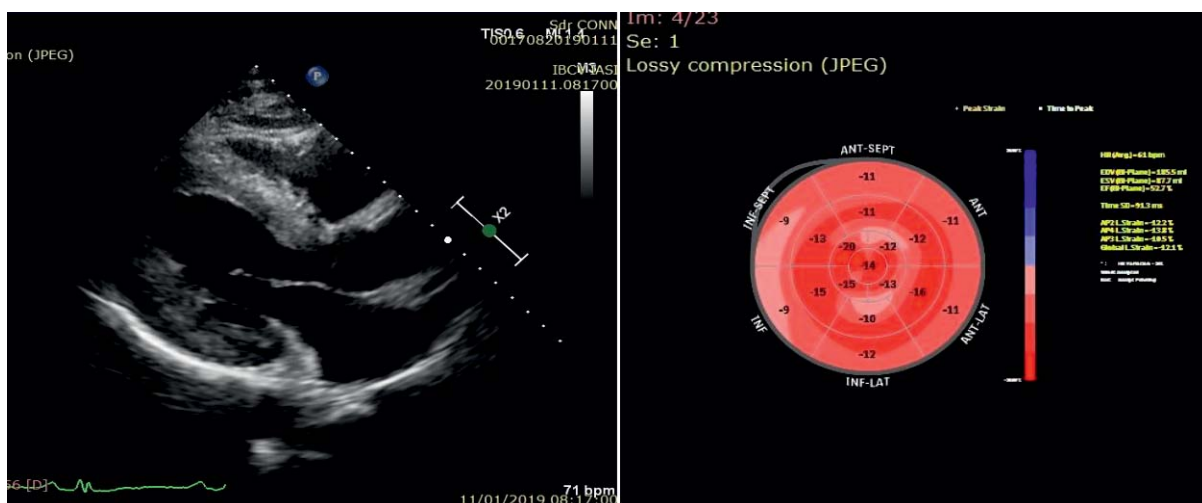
Transthoracic echocardiography, left: parasternal long axis view, LV hypertrophy; right: speckle tracking-longitudinal LV systolic dysfunction.
